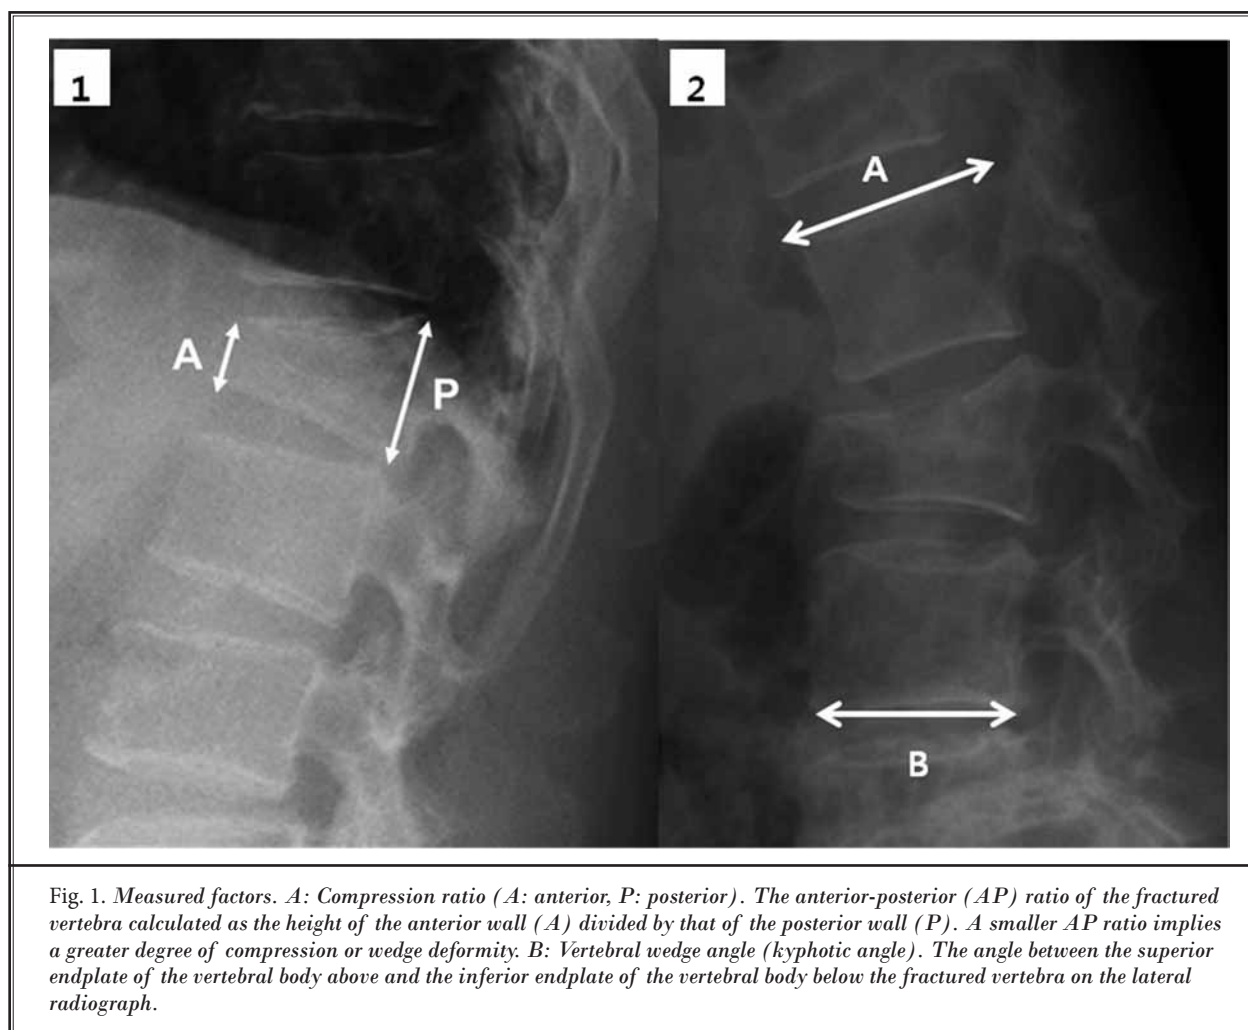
Measured factors. A: Compression ratio (A: anterior, P: posterior). The anterior-posterior (AP) ratio of the fractured vertebra calculated as the height of the anterior wall (A) divided by that of the posterior wall (P). A smaller AP ratio implies a greater degree of compression or wedge deformity. B: Vertebral wedge angle (kyphotic angle). The angle between the superior endplate of the vertebral body above and the inferior endplate of the vertebral body below the fractured vertebra on the lateral radiograph.
